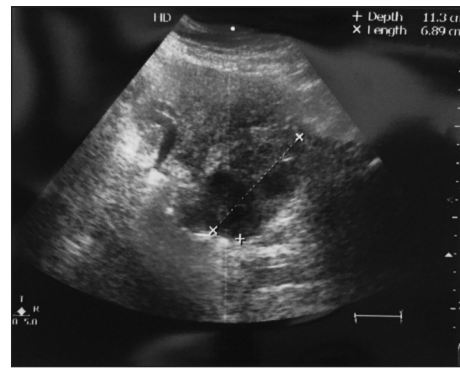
Ultrasonographic appearance of the adnexial mass.
